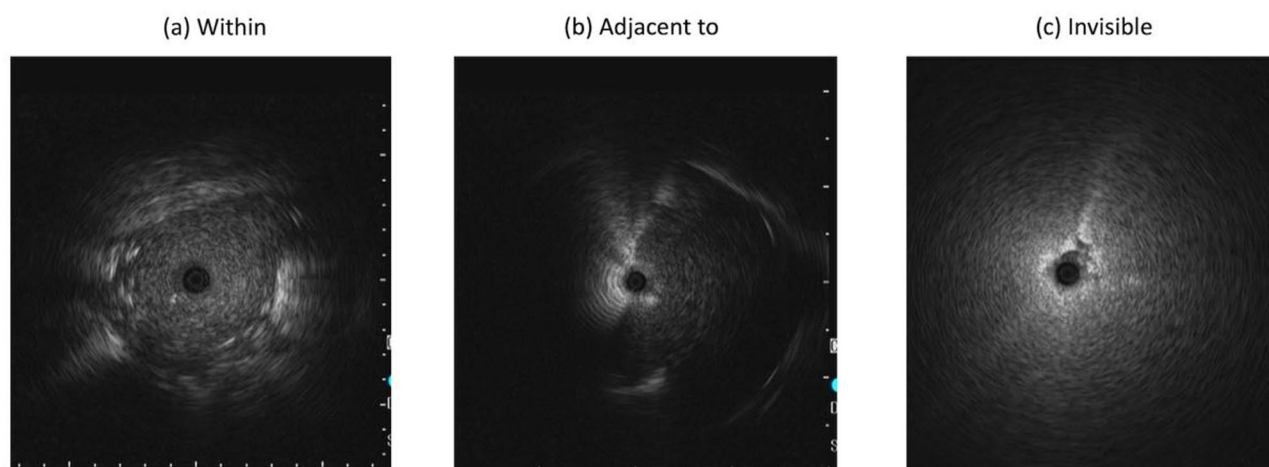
Representative radial endobronchial ultrasound (R-EBUS) images based on probe–lesion relation. R-EBUS images showing the three positional categories based on the relation between the ultrasound probe and peripheral pulmonary lesions: (a) “Within” – The probe is positioned inside the lesion, completely surrounded by the lesion; (b) “Adjacent to” – The probe is in contact with the lesion, partially surrounded by the lesion; (c) “Invisible” – The probe is away from the lesion, showing minimal or no visualization of the lesion margin. These classifications were used to determine whether intraoperative improvements in R-EBUS findings (from “invisible” to “adjacent” or “within,” or from “adjacent” to “within”) affected diagnostic yield. All the images were acquired with the 20 MHz radial-probe EBUS described in the Methods section
